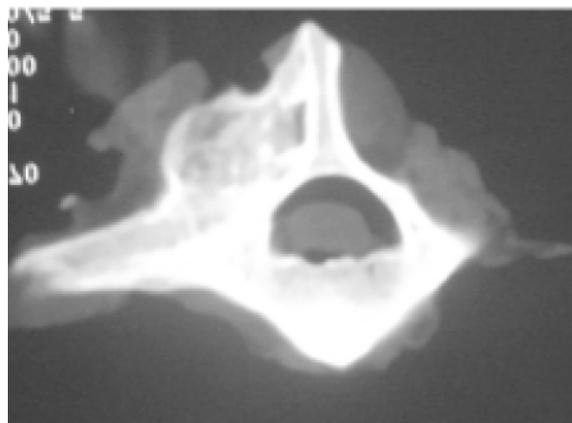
A CT scan showing sufficient solid fusion in the L2-3 spinal segment where particulate magnesium metal was employed.²³⁾
